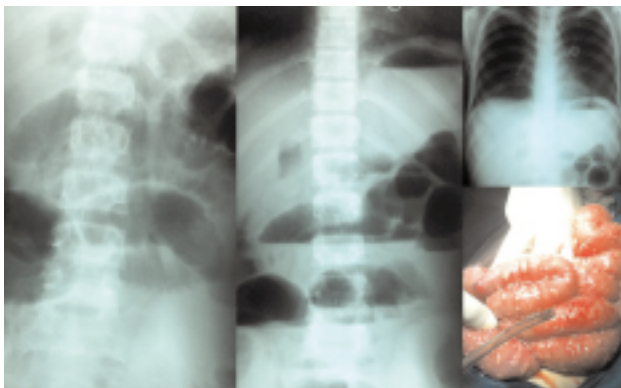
X-ray abdomen in erect and supine position showed dilated loops alongwith multiple fluid levels.
